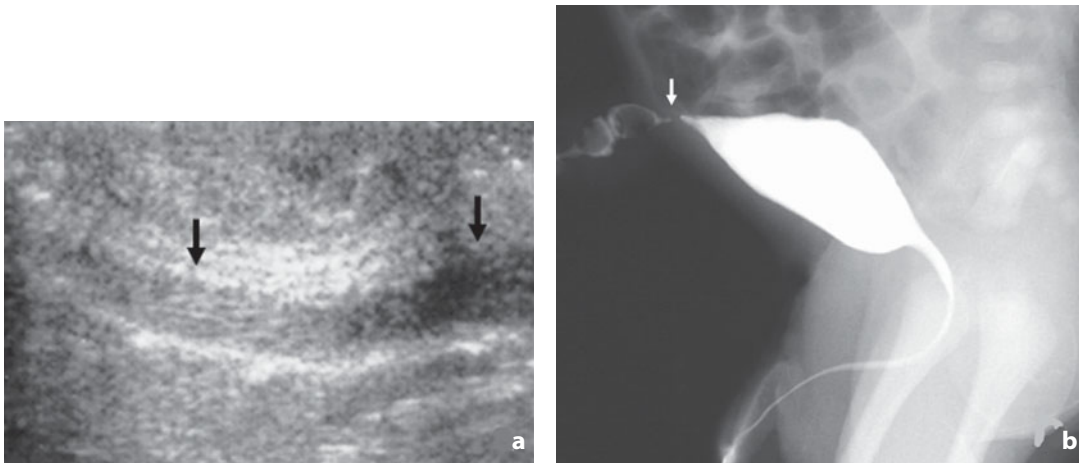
Patent urachus. a Longitudinal supravescical sonogram shows an iso-hypoechoic tubular structure (*arrows*) at the site of the medial umbilical ligament. b Voiding cystourethrography shows the communication between the bladder and the umbilicus with leakage of contrast medium from the latter (*arrow*)
